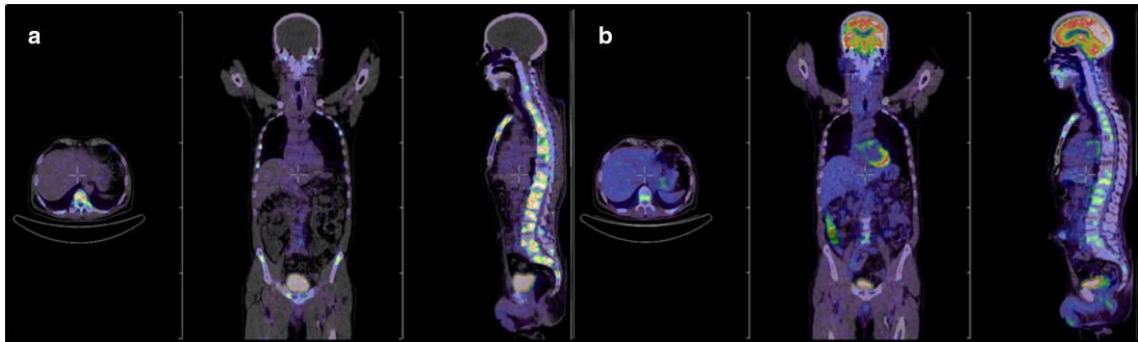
Comparison of PET/CT images of a. [^{68}Ga]Ga-DOTAZOL with b. [^{18}F]FDG in patient with skeletal metastases secondary to bronchial carcinoma.
